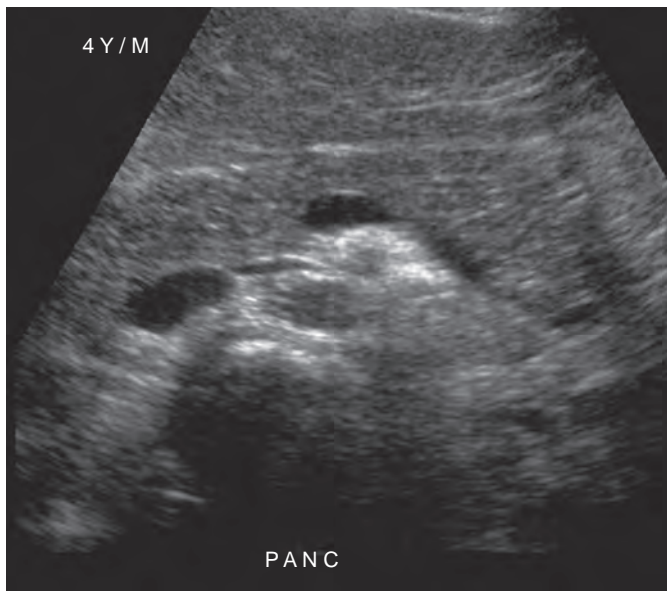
Normal pancreas. The transverse ultrasound image of the pancreas demonstrates pancreatic echogenicity similar to that of the adjacent liver.
